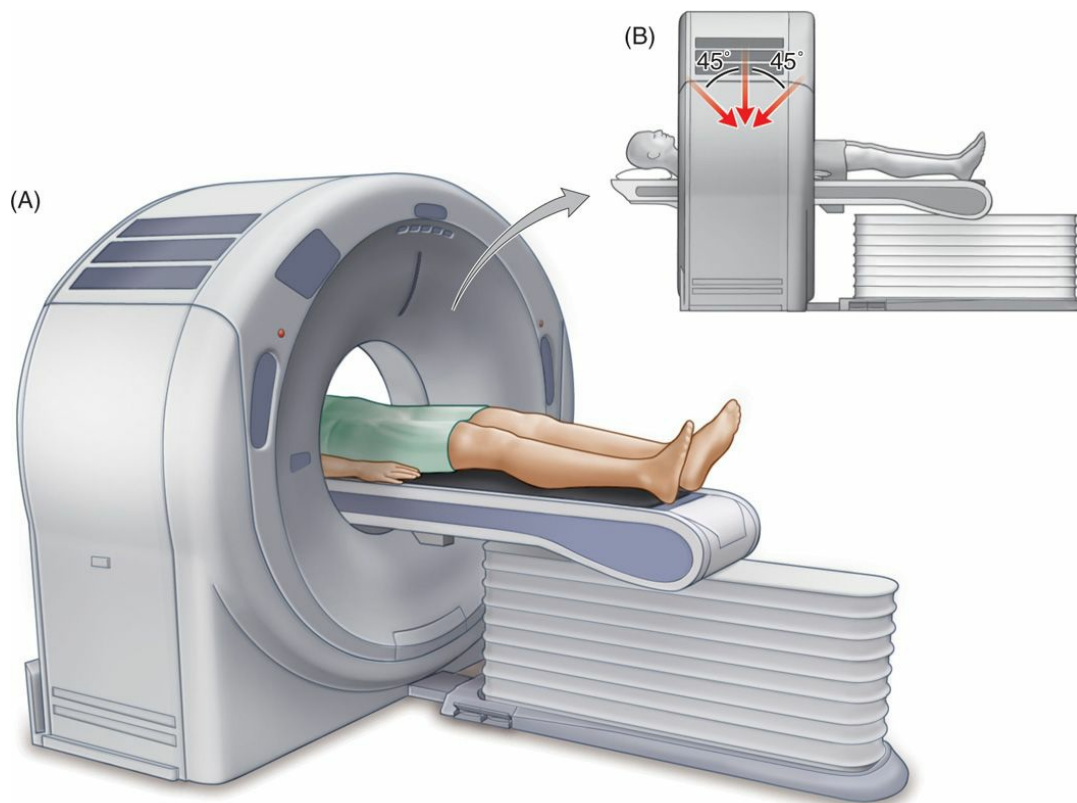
The angled gantry approach. (A) The traditional CT gantry position is perpendicular to the CT table. (B) Angling the CT gantry along the line of an angled needle trajectory allows the entire needle trajectory to remain along a single CT slice.
